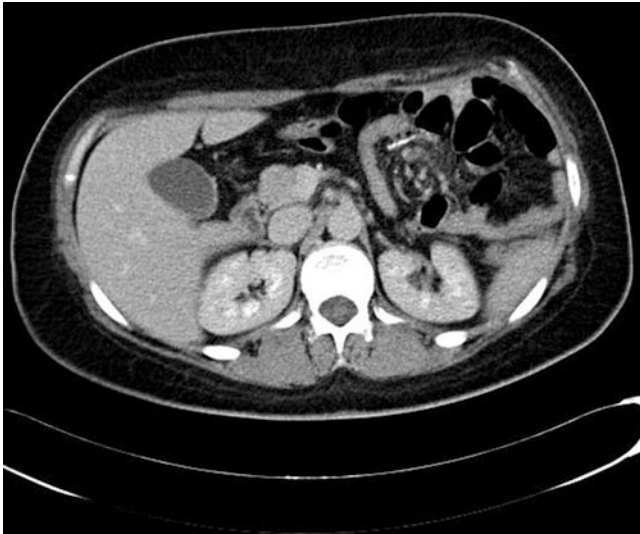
Axial CT demonstrating Petersen's hernia with swirling of the mesentery evident in this image. Small bowel is seen herniating above the level of the stomach. There is a potential space posterior to the gastrojejunostomy where this herniation occurs. Radiopaedia.org (<http://radiopaedia.org/cases/peterserns-hernia>), case ID: 14053
